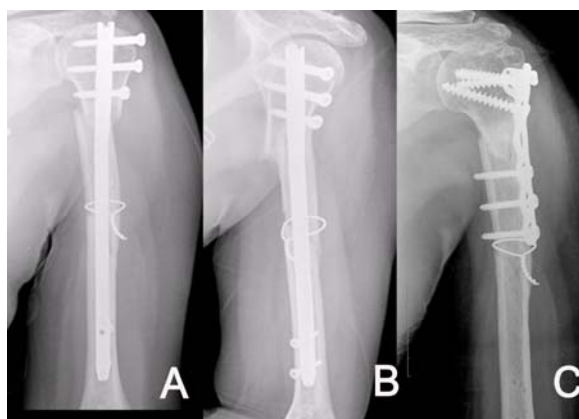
A 49-year-old lady (case No. 1) sustained fracture after road traffic accident: A) Plain radiographs showed ipsilateral humeral neck (two part surgical neck fracture, Müller AO Classification A32) and shaft fracture (Müller AO Classification A32). This was initially treated with antegrade intramedullary nail; B) persistent fracture gap seen was developed at 3 months after the operation with re-displacement of fracture fragment and screw loosening; C) Revision surgery was performed with proximal humeral locking compression plate and autogenous bone graft, which resulted in union three months after the revision surgery.
